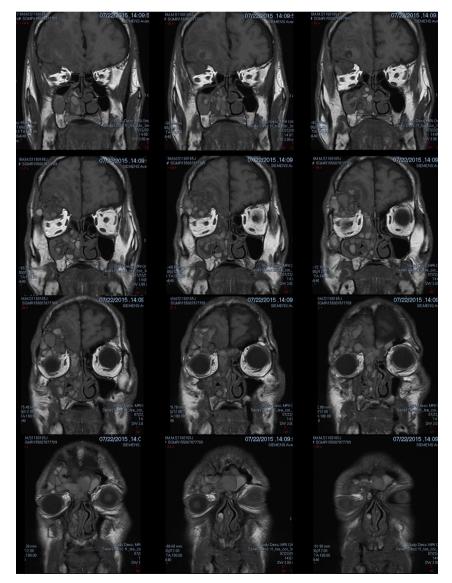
MRI (T1 sequence) showing consecutive images of frontal sinus mass from posterior to anterior.
